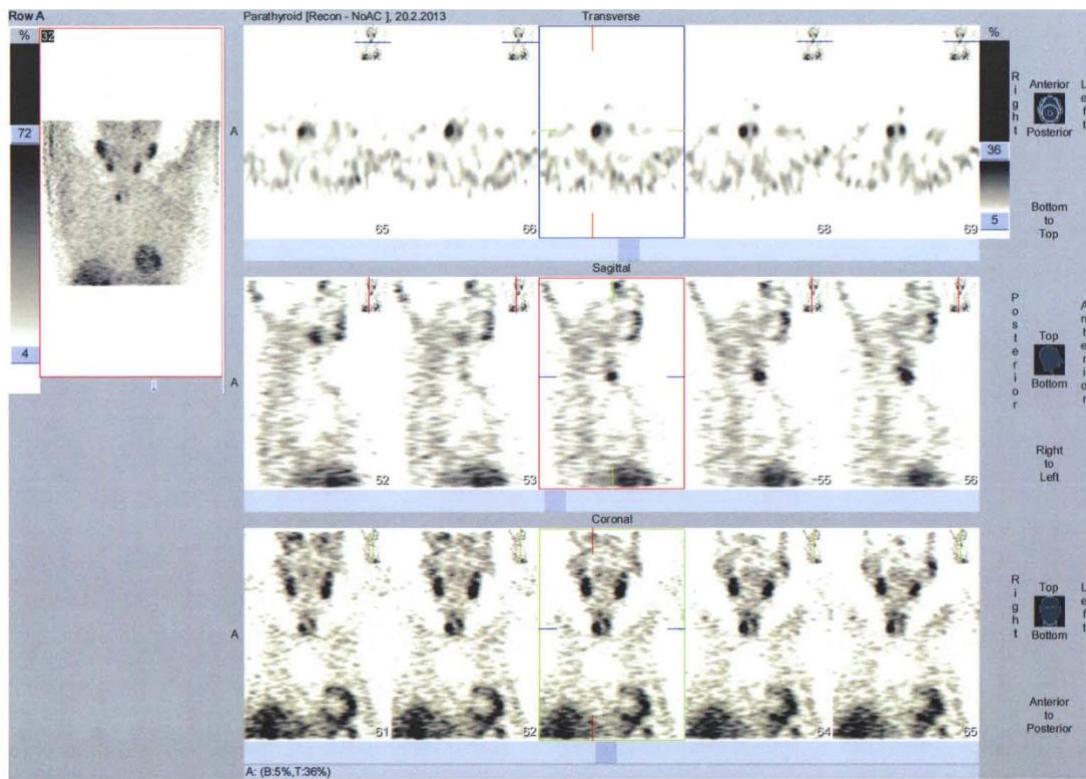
On the early SPECT images a hyperfixating zone in the caudal part of the right thyroid lobe is visualized
